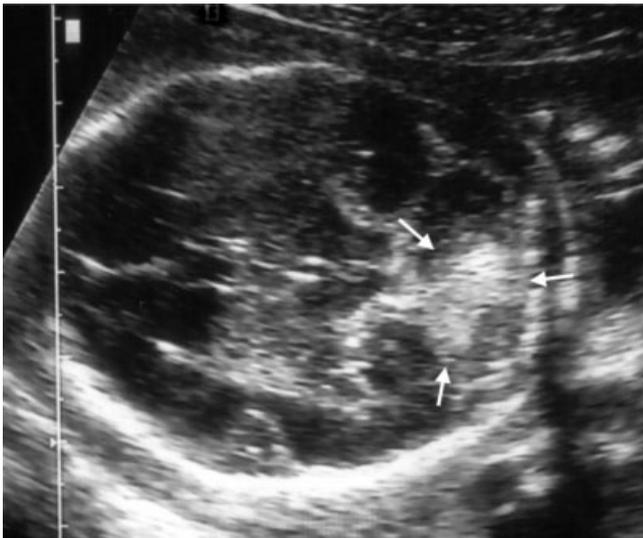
Ultrasound image of an axial transcranial scan of the fetal cranium at the level of the thalami and superior vermis. Sonographically the intracerebellar hemorrhage appeared as a bright echogenic area confined to the superior vermis and left cerebellar lobe (arrows).
